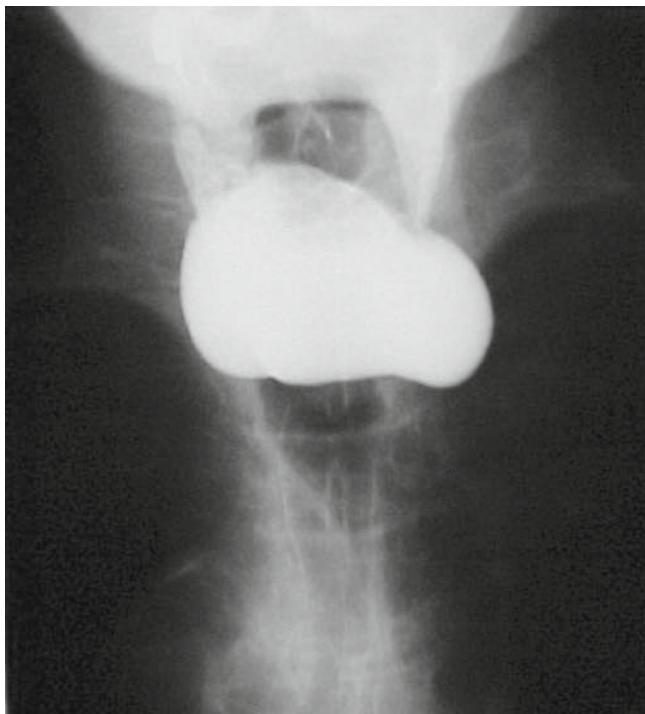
Barium radiograph of Zenker diverticulum
